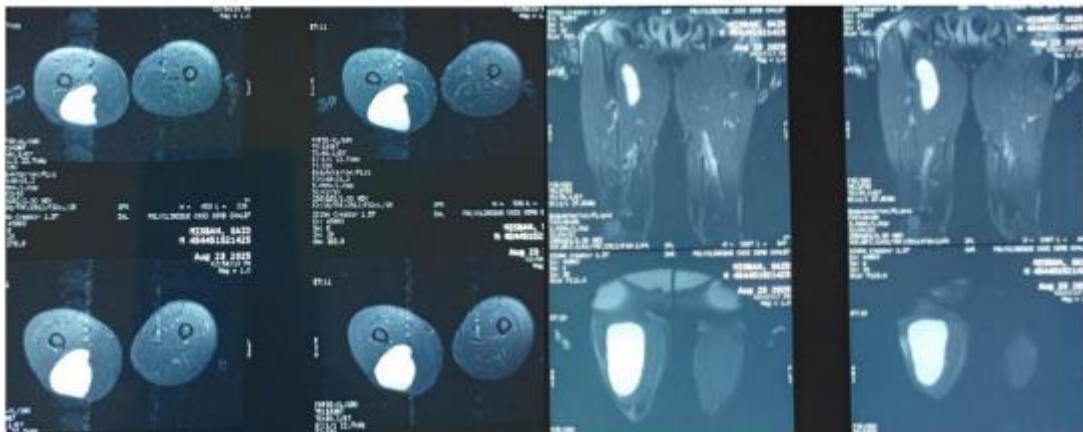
Magnetic resonance imaging demonstrating the sciatic nerve tumor.
